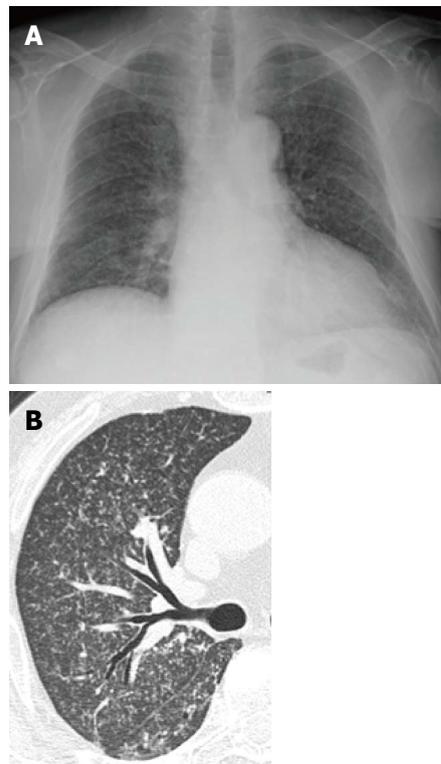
Miliary tuberculosis in a man in his 60s. A: Chest radiograph diffuse reticulonodular opacities in both lungs; B: Thin-section computed tomography demonstrates diffuse miliary nodules with a random distribution.
